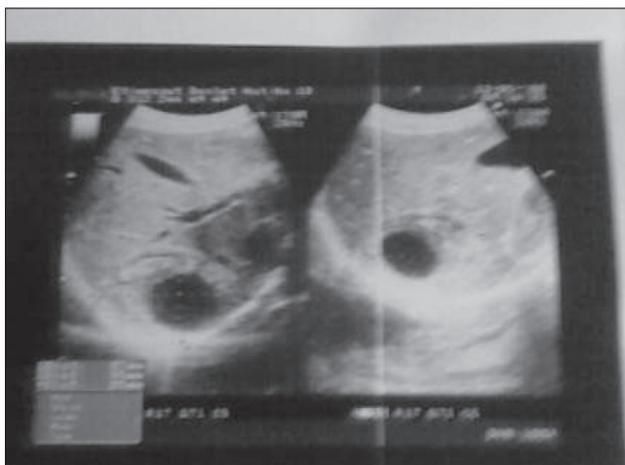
Ultrasonographic appearance of hepatic cysts.
